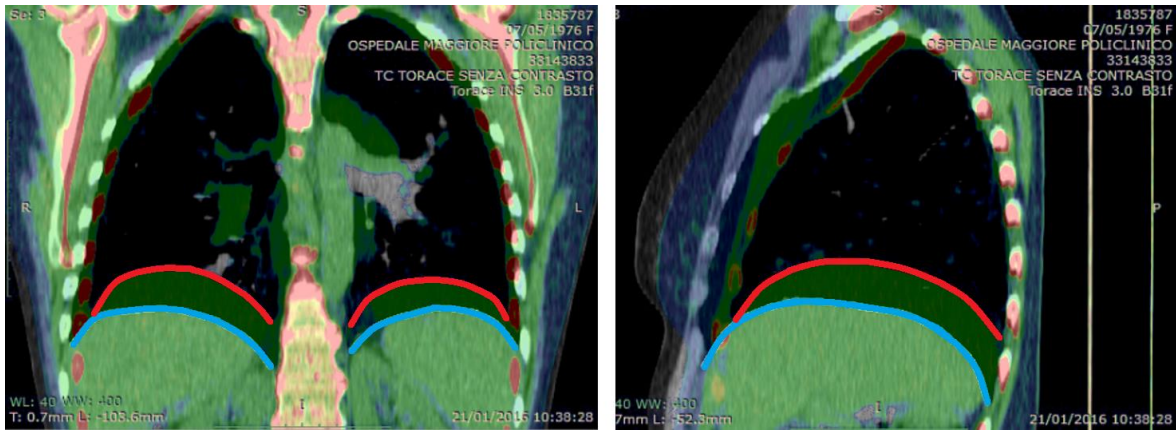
Overlapping of CT images taken at TLC (green) and RV (red) of a pulmonary fibrosis patient.
